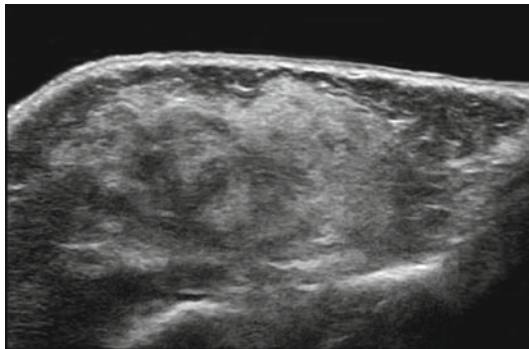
(a–f) Hemangioma in proliferative phase. (a) Clinical image of a lesion in the chin. (b) Ultrasound image (gray scale, transverse view) shows hypoechoic mass (*) that involves dermis and subcutaneous tissue. (c) Color Doppler ultrasound image (transverse view) demonstrates high presence of vascularity within the mass. (d) Ultrasound image (gray scale, transverse panoramic wide view) shows the hypoechoic mass
